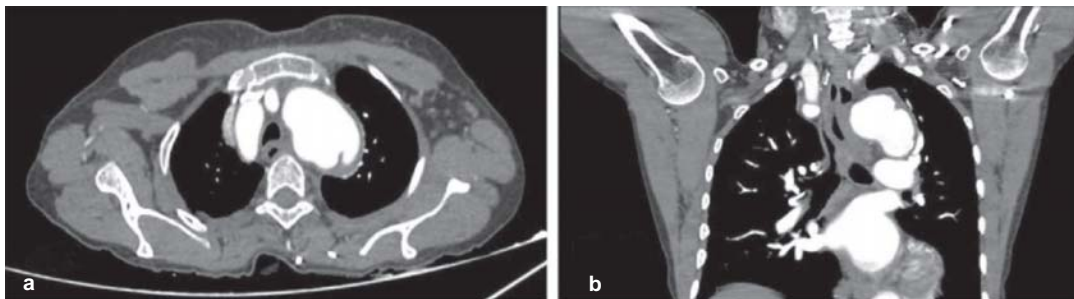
Axial (a) and coronal (b) computed tomography images of the thorax at the level of arch of aorta showing a small aneurysm of the aortic arch
